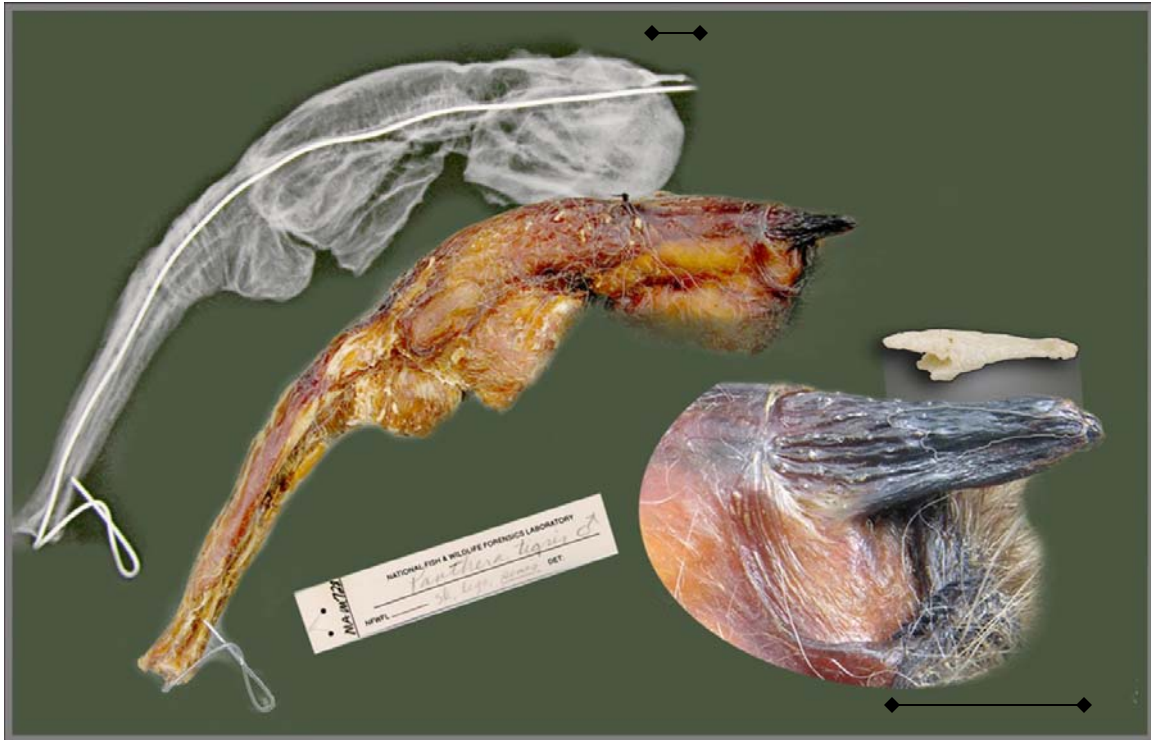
Dried tiger penis, whole (upper as x-rayed and middle as photographed), and close-up of tip (lower right), showing the approximate position of the internal penis bone, also known as a baculum. Both scale lines represent approximately 2 cm.
